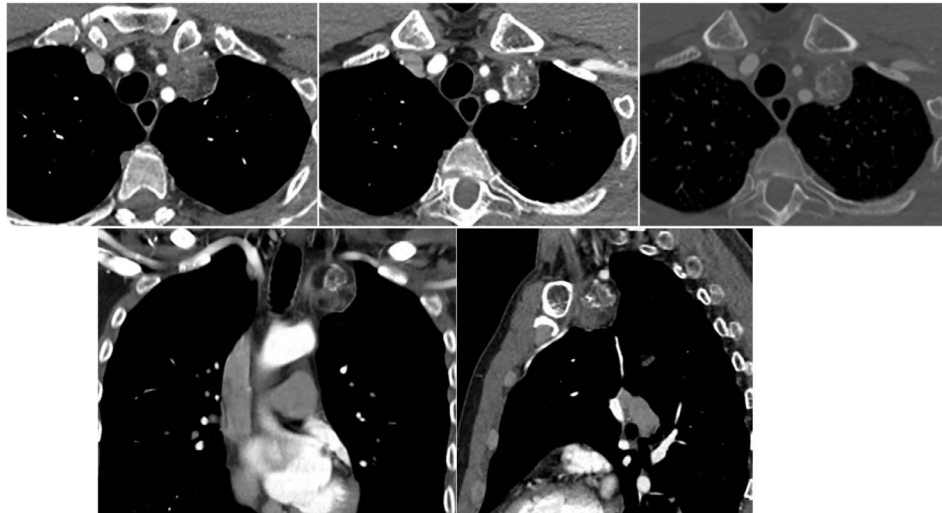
Contrast enhanced axial CT of the chest, and coronal and sagittal reformations demonstrate a well-defined left anterior mediastinal mass containing fat, soft tissue of muscle attenuation, and irregular calcifications—imaging characteristics suggestive of a mature teratoma.
